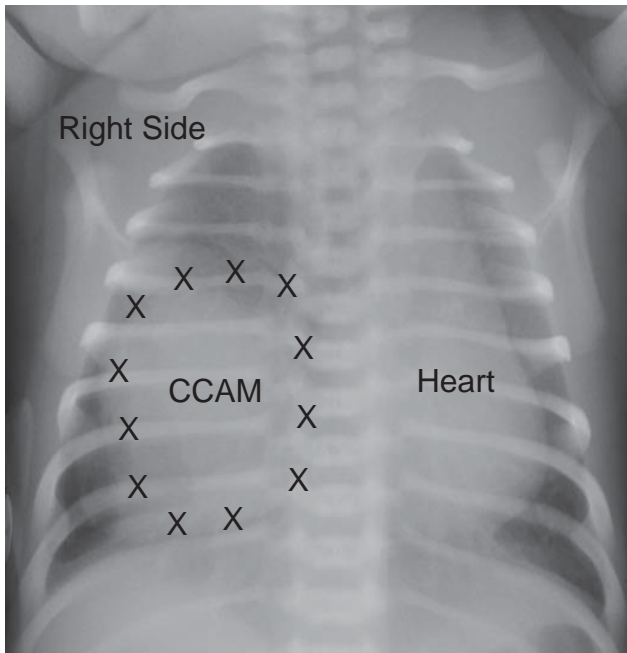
Chest X-ray of CPAM taken shortly after birth. The CCAM is on the infant's right side and is pushing the heart to the right side of the chest.
